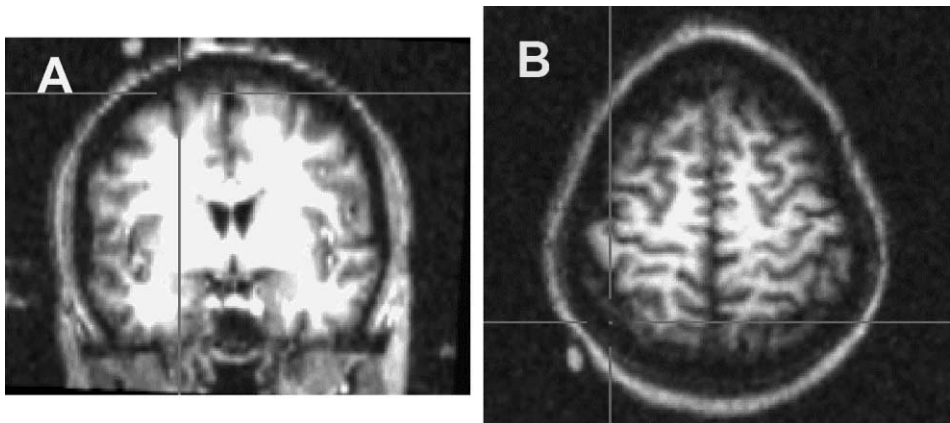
TMS location sites over the PMC (A) and PPC (B) determined by three-dimensional MRI for a single subject using high-intensity signal markers.
